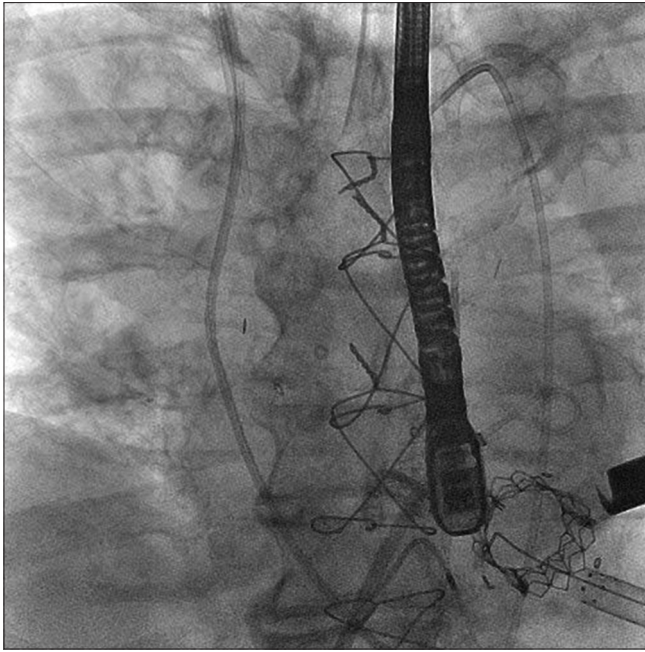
Fluoroscopic view of deployed “valve in valve” mitral and aortic valves in position with transesophageal echocardiography probe, pulmonary artery catheter previous sternotomy wires and valve delivery sheath in left ventricular apex
